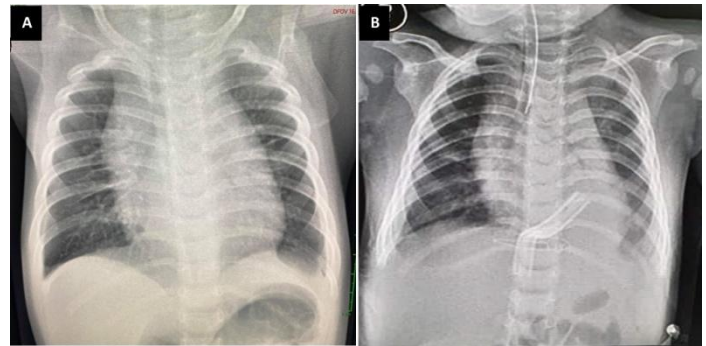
A. Initial Chest X-ray showing cardiomegaly with a computed cardiothoracic ratio of 0.63, and minimal streaky densities in the right lower lobe signed out as pneumonia. B. Repeat Chest X-ray on APL view on the 3rd post-operative day showed decreased CT ratio (0.56), also visualized was the JP-tube within the pericardial space.
